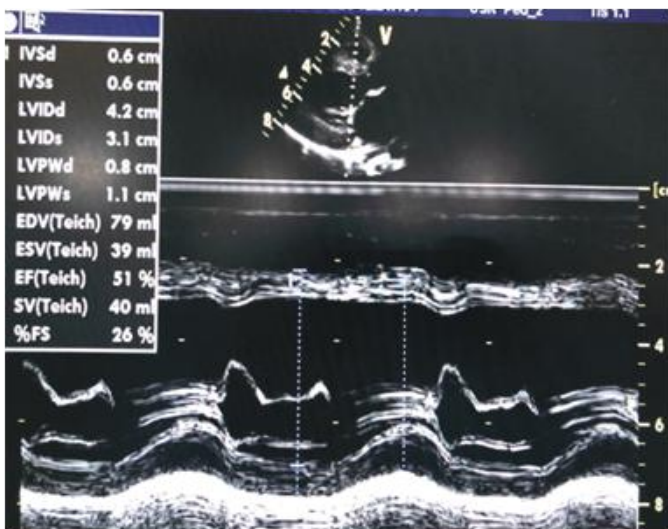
Post procedure left ventricular dysfunction revealed by echocardiography (LVEF 53%)
